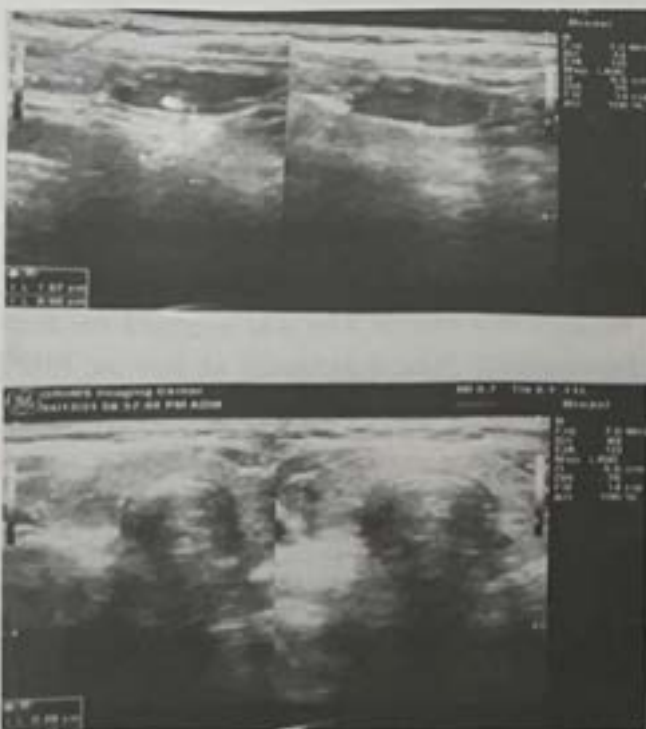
Ultrasonography of neck showing parathyroid adenoma
